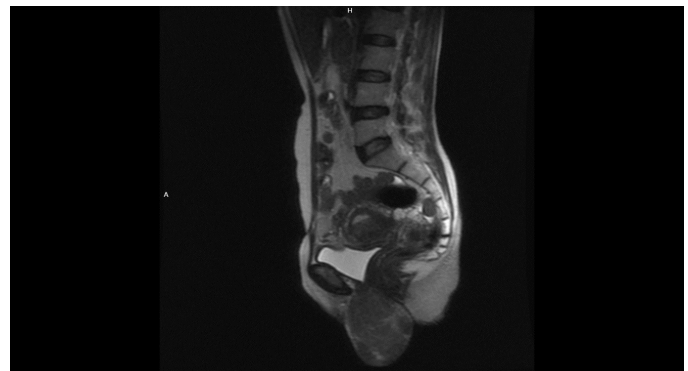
Magnetic resonance imaging showed the presence of a 6 cm mass that displaced the urethra anteriorly and protruded from the vagina
